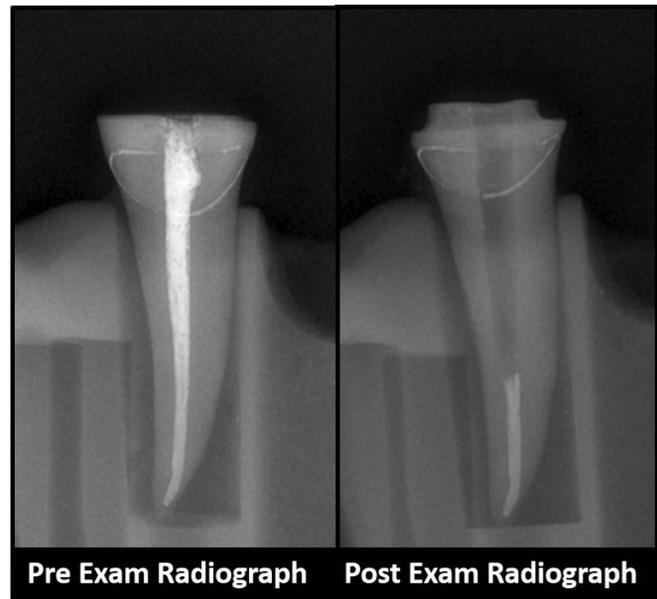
Radiographs recorded before and after the post space preparation.
